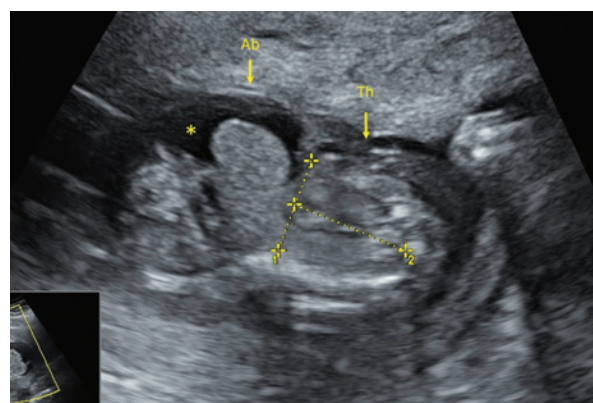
Two-dimensional sonography of the fetus at 18 weeks of gestation. Sagittal view. Narrow thorax (Th) and expanded abdomen (Ad) with ascites*.
